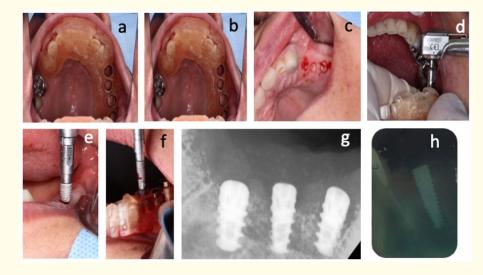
Photographs of surgical guide direct source a) seating of the surgical guide b) reduction cylinders c) drilling was performed d) finished drilling e) placement of the implant without guide, f) (flapless) and placement of implants g and h) periapical x-rays, to verify their position in the vertical direction and parallelism between the implants.
